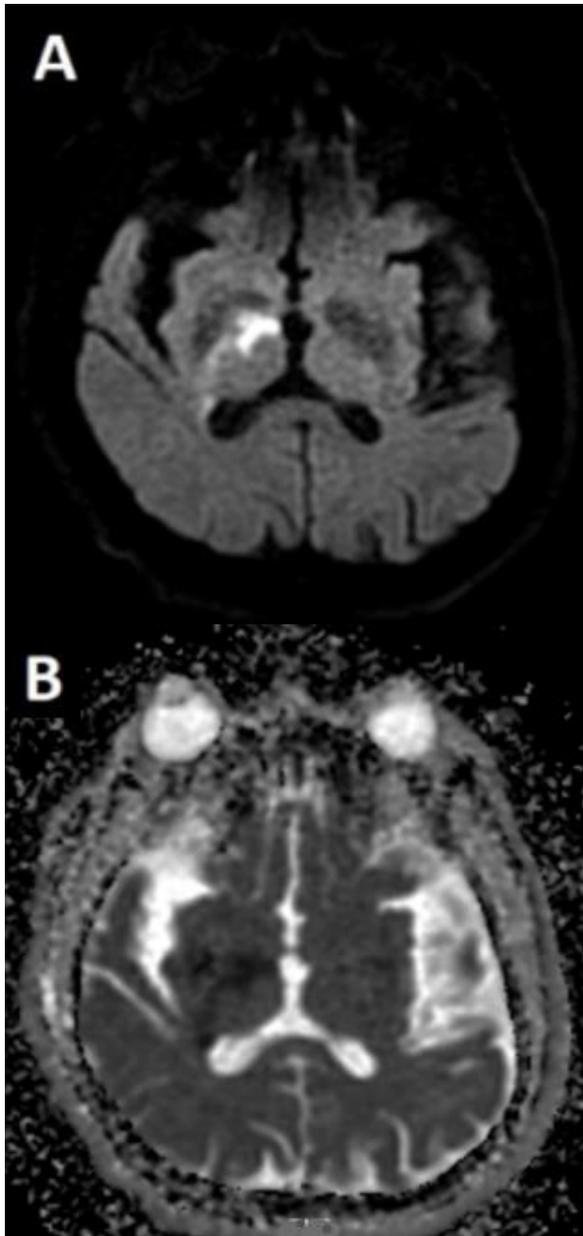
In diffusion MRI, a lesion compatible with acute infarction is observed in the globus pallidus at the level of the right basal ganglia, hyperintense at b1000 sequence (A) and hypointense at ADC sequence (B).
